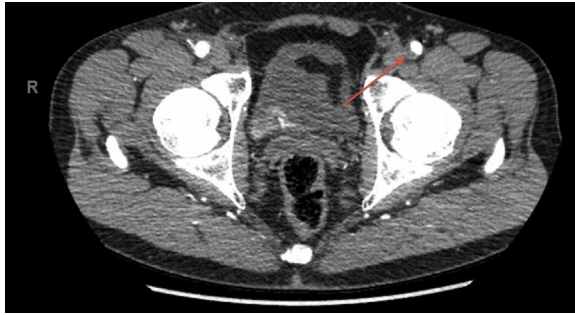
CT angiogram showing heterogeneous plaque in the left common femoral artery (red arrow).
